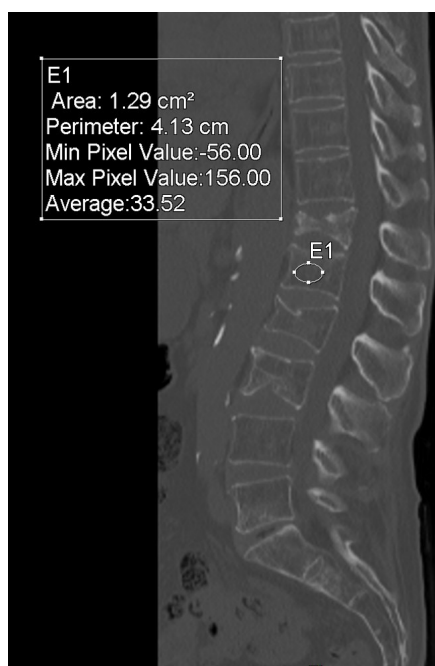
Coronal non-enhanced CT reconstruction in bone window reveals a vertebral attenuation of 33,5 HU in L1, consistent with osteoporosis.
